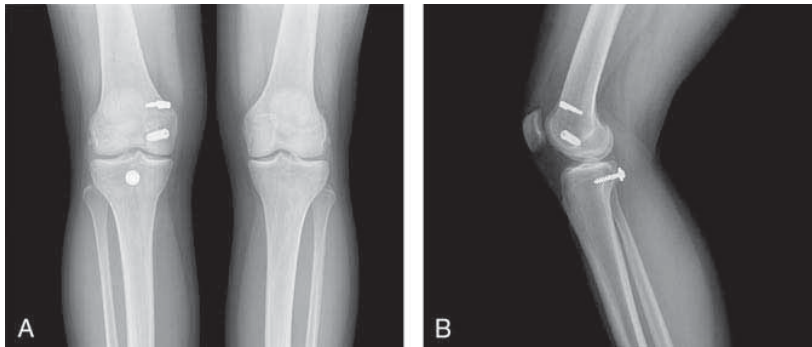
Radiographic AP (A) and lateral (B) views of a single-bundle inlay PCL reconstruction.
